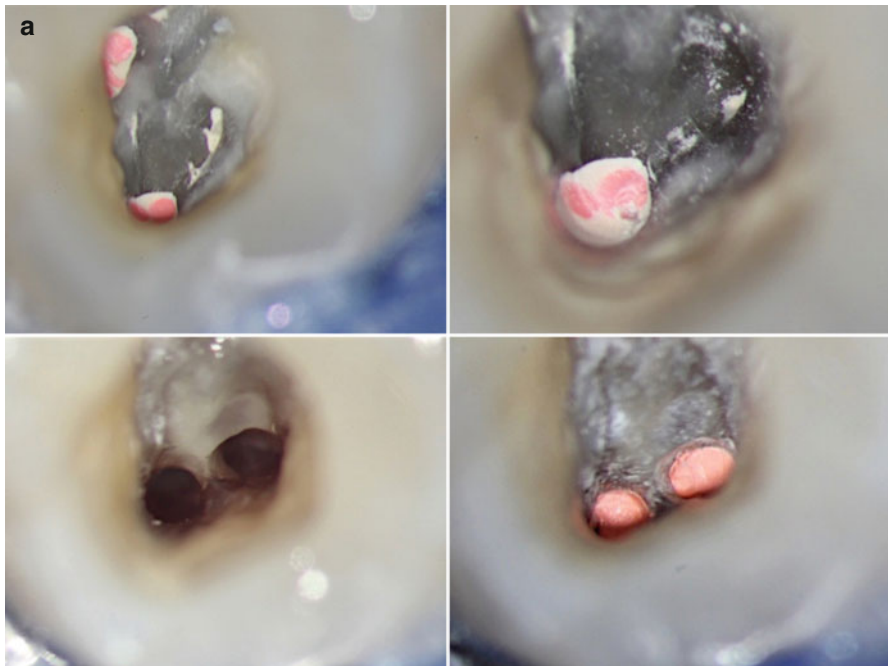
(a) Clinical image during endodontic retreatment of a first maxillary molar with untreated MB2. The location identification of MB2, the access, preparation, and also filling of the canal system after retreatment of MB1 is shown. (b) Corresponding CBCT scan prior to retreatment of the first maxillary molar is shown in (a). Note the unprepared and unfilled MB2 depicted in different slices of the original dataset (*arrows*)
